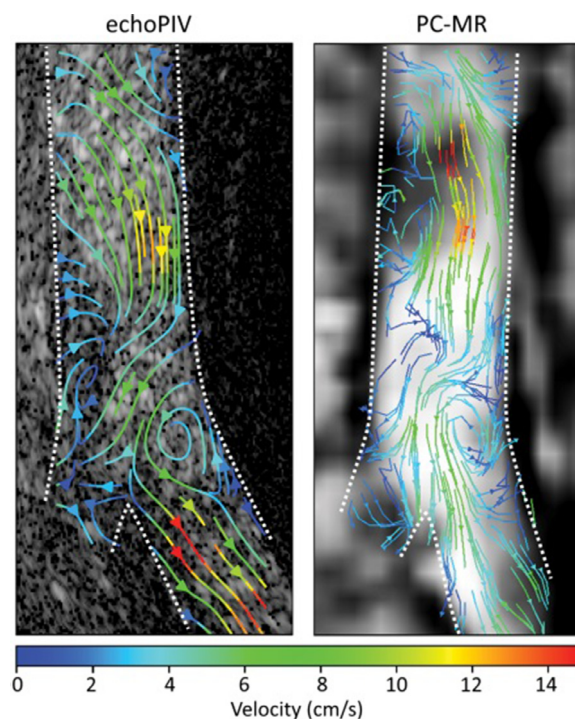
Streamline representation of blood flow velocities during early diastole of the abdominal aorta of a volunteer. Left: High-frame-rate contrast-enhanced echography. Right: Phase contrast magnetic resonance imaging. Similar flow patterns can be observed, including a slow (counterclockwise) recirculation zone near the origin of the left common iliac artery. *Dashed lines* indicate estimated delineation of the vessel wall. echoPIV = echo particle image velocimetry; Reprinted with permission from Engelhard *et al.* (2018).
